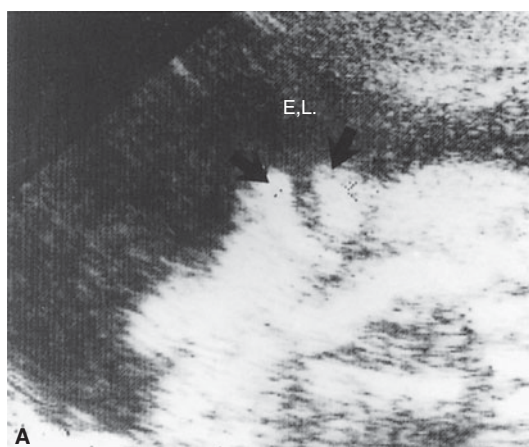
Atrophy of the eyelids (A) Eyelids (EL). The upper and lower eyelids (arrow) were small and open throughout the ultrasound (US) examination. Partial atrophy was therefore suggested. (B) The aborted fetus with Neu-Laxova syndrome. There is partial atrophy of the eyelids, as well as cataract.
